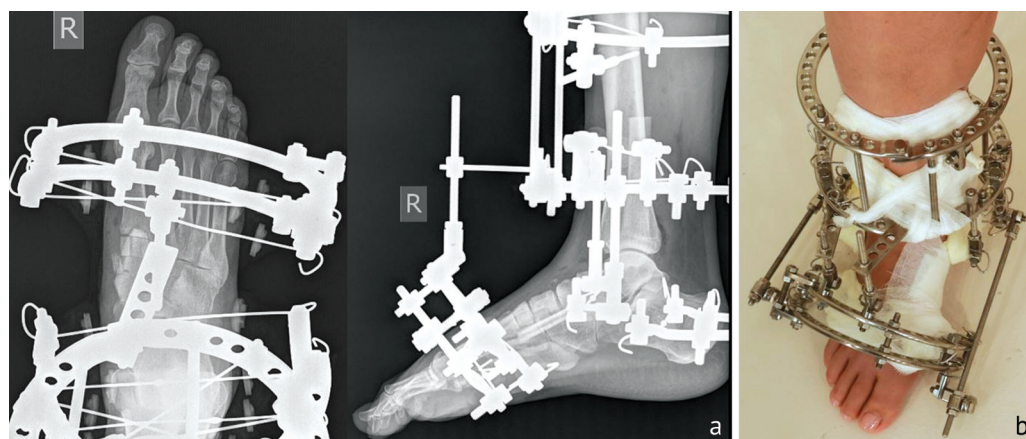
Treatment: a – X-rays in AP and lateral views; b – photo of the right foot after the operation
